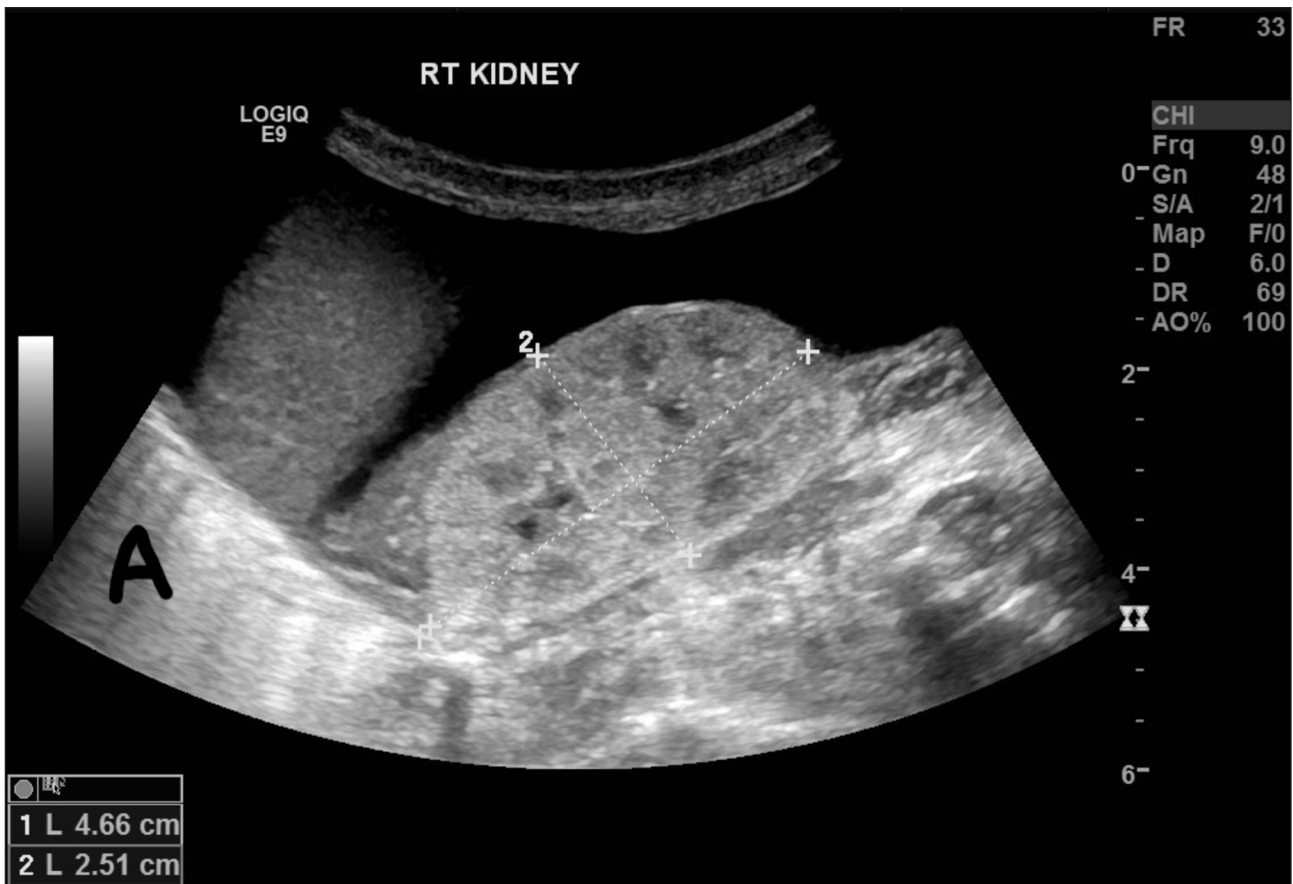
Abdominal ultrasound showing massive ascites and normal kidney.
